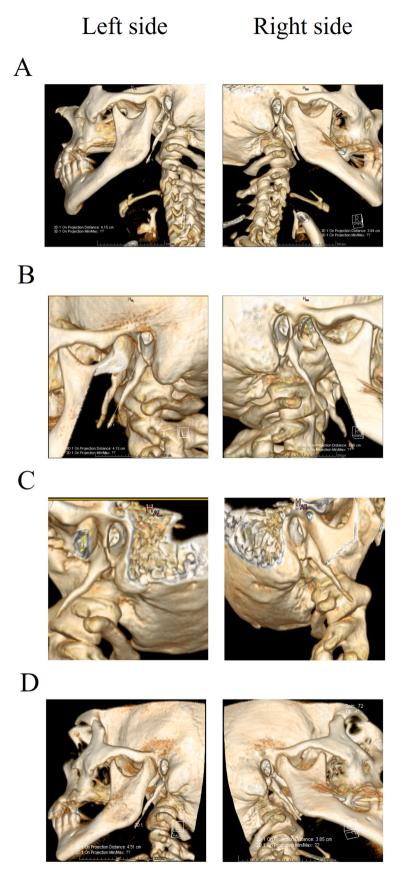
Computed tomography (CT) images of the styloid process length over the years. (A) 17th April, 2014; (B) 16th June, 2015; (C) 10th, November 2016; (D) 14th March, 2018.
